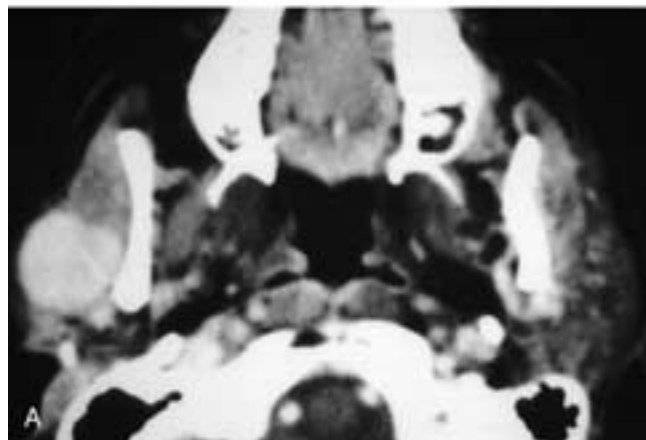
Axial contrast-enhanced CT scan (A) shows a well-delineated mass in the superficial portion of the right parotid gland. Axial T2-weighted MR image (B) shows this pleomorphic adenoma equally well. Although this may occur, the tumor margins usually are better seen on an MR study.
